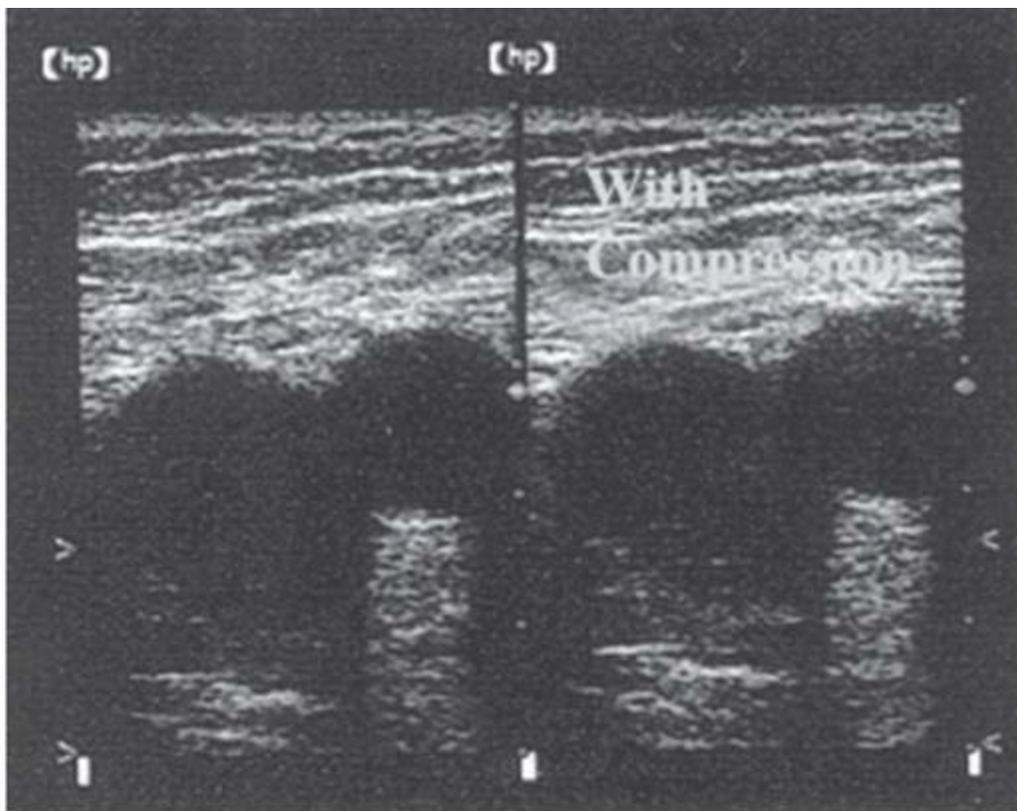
B-mode ultrasound of the femoral vein in cross-section. The femoral vein does not compress.
